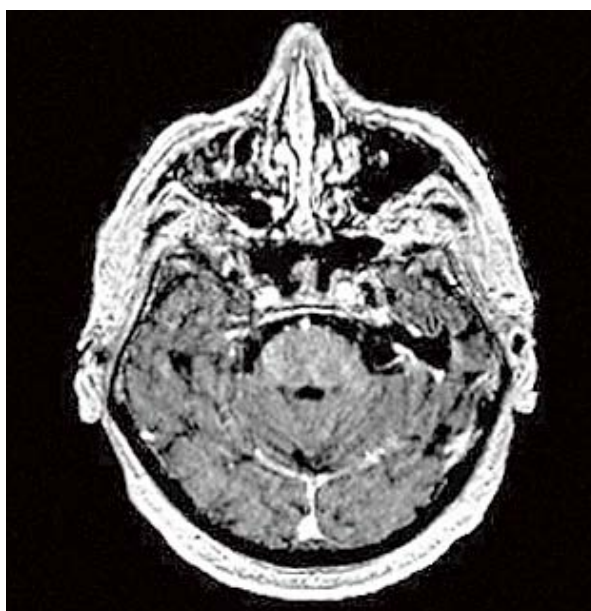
Axial contrast-enhanced T1WI MRI shows punctate foci of contrast enhancement in the pons.
